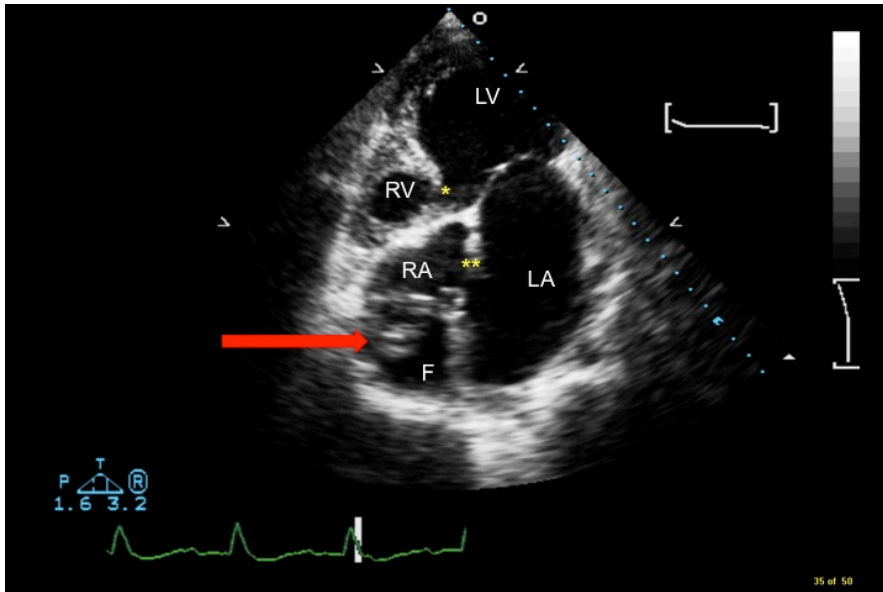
Transthoracic echocardiography on admission, showing the right atrium (RA), left atrium (LA), right ventricle (RV), left ventricle (LV), atrial septal defect (), ventricular septal defect (*), Fontan lateral tunnel (F), and mural thrombus in lateral tunnel (red arrow).
